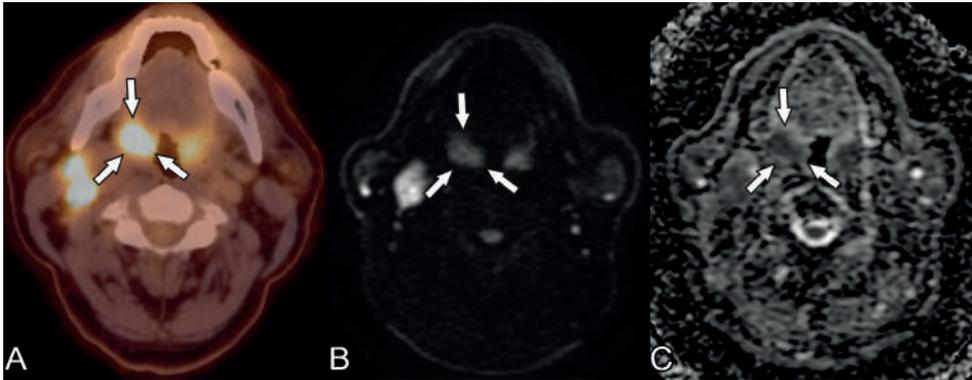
Imaging of a 56-year old male patient who presented with a progressive nodal swelling on the right side and initial unknown primary tumor and who was finally diagnosed with a T1N2b tonsillar carcinoma. A) ^{18}F -FDG-PET-CT shows higher ^{18}F -FDG uptake of the right tonsil compared to the left tonsil. B) On b1000 imaging and the C) ADC map the right tonsil has a slightly lower ADC value compared to the left tonsil ($1.05 \cdot 10^{-3} \text{ mm}^2/\text{sec}$ vs $1.16 \cdot 10^{-3} \text{ mm}^2/\text{sec}$) combined with a slightly larger right tonsil compared to the left tonsil.
